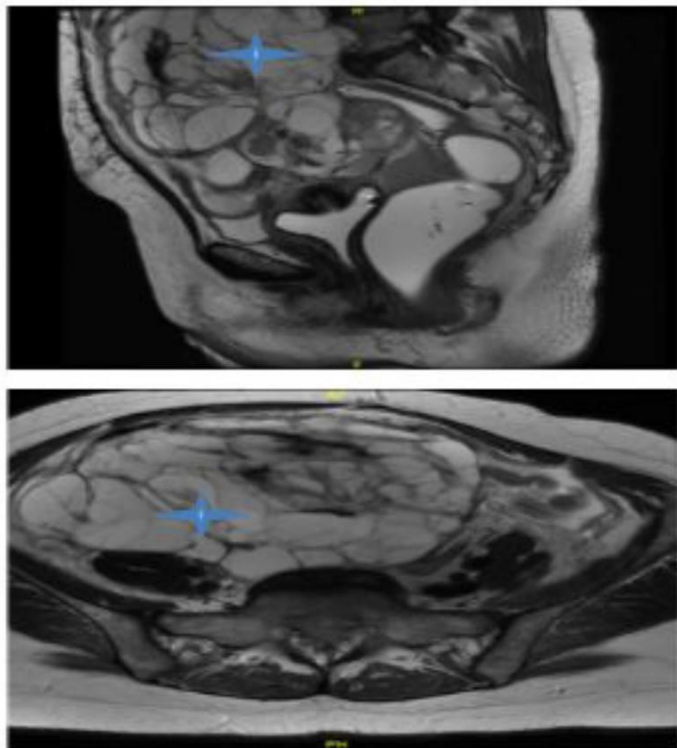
MRI sagittal view T2 (up) and axial view T2 (down).
